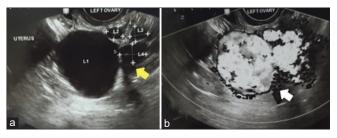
Noninstitutional ultrasound: Initial transvaginal ultrasound. (a) Grayscale image showing multiple cystic structures at the left adnexa, yellow arrow. (b) Color Doppler showed abundant color
